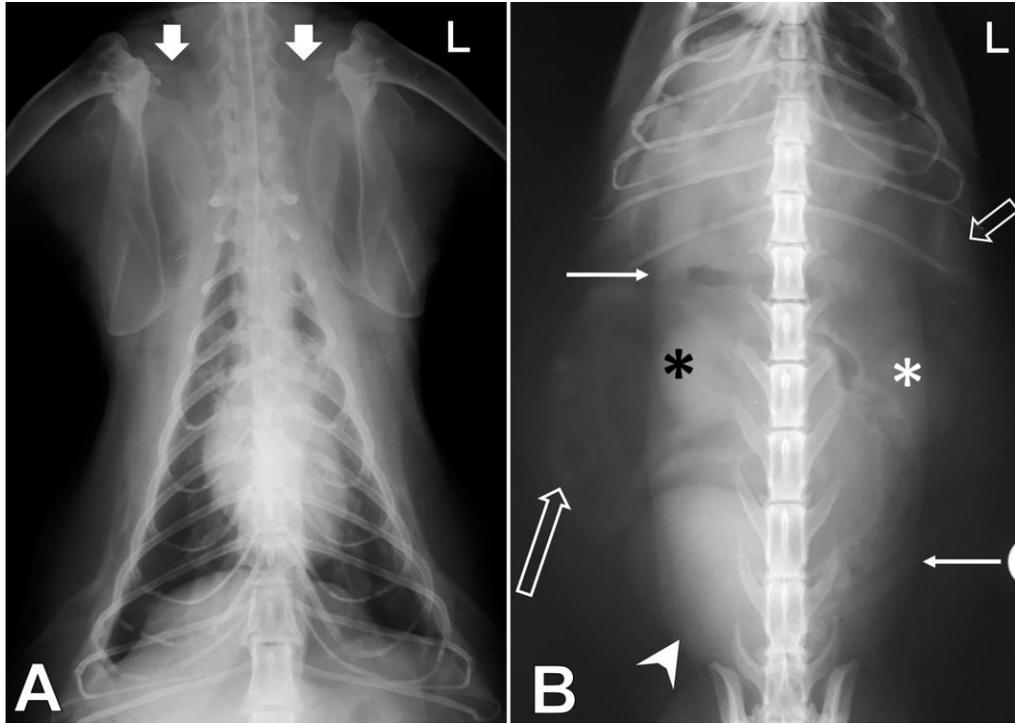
A: Dorsoventral thoracic radiograph of caracal I (12.8 kg; 5.3 yrs). B: Ventrodorsal abdominal radiograph of caracal II (14.8 kg; 8.8 yrs). A: The apex of the cardiac silhouette is positioned in the left hemithorax. The clavicles are indicated by thick white arrows. B: Hypaxial muscles are conspicuous (long white arrows). The right kidney (black asterisk) is more cranial than the left kidney (white asterisk). Note the bunching of small intestines in the right abdomen (long white open arrow). The spleen and urinary bladder are indicated by a short white open arrow and white arrow head, respectively. L= left.
